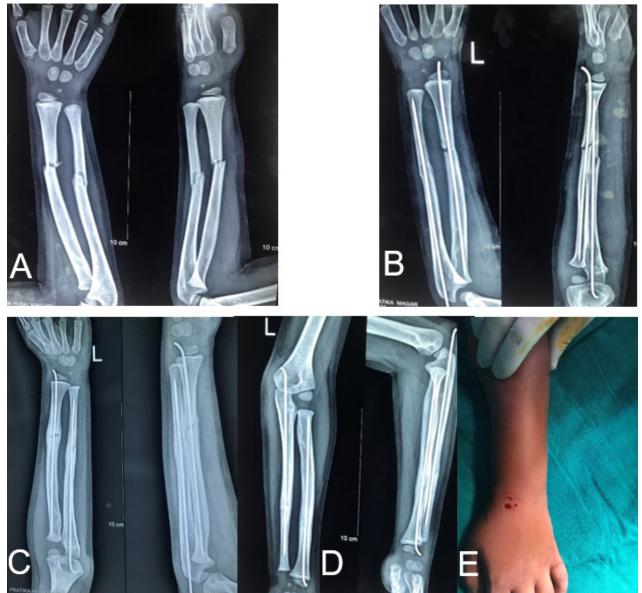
Case 2: Preoperative Xray of 5 years old children AP and presumed Lateral view showing both ulna and radius fractures (A); Postoperative Xray at 3 weeks (B); Xray at 6 weeks (C); Xray at 3 months (D); Punctured wound at wrist after burial of K wire in wrist (E)
